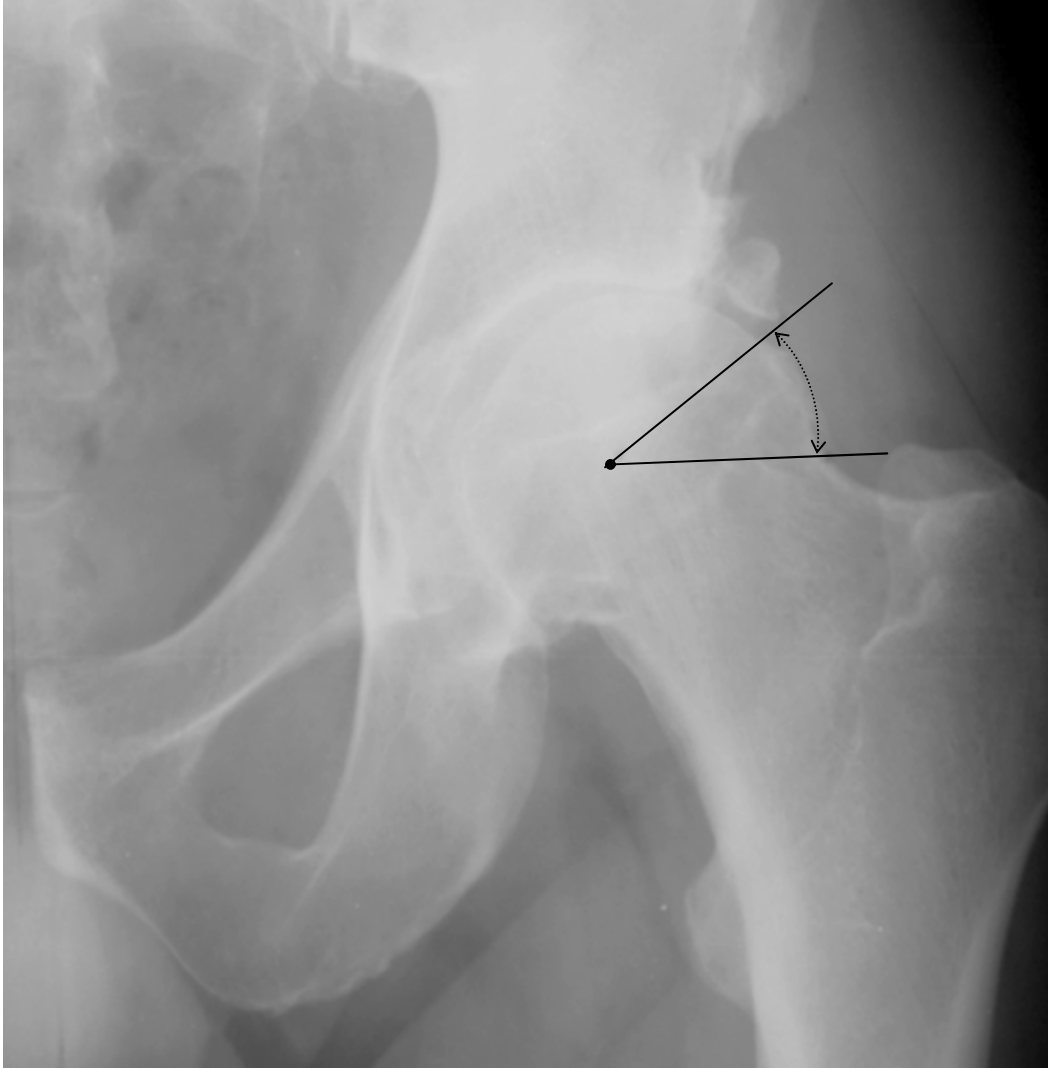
Radiograph of a hip joint showing CAO; the lines determining the "free-angle" are inserted.
